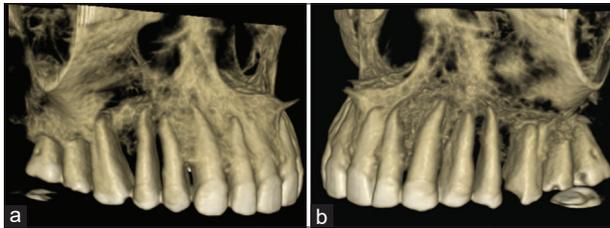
(a and b) Three-dimensional cone-beam computed tomography images showing perforation of buccal and lingual cortical plates of the right and left maxilla of the same case
